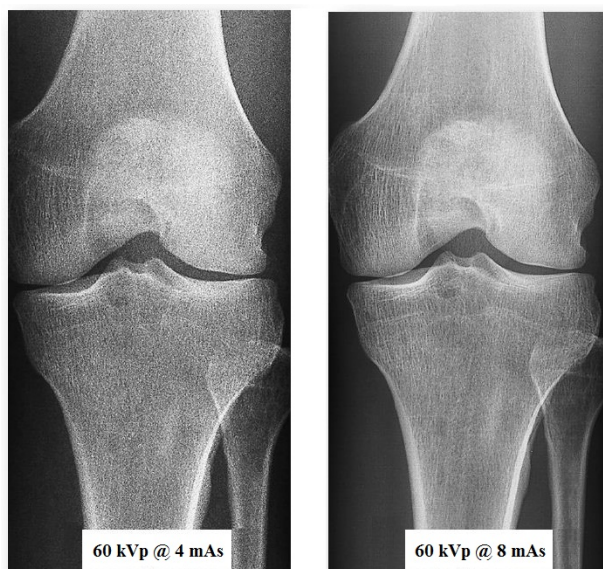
Quantum noise in a knee radiograph.
